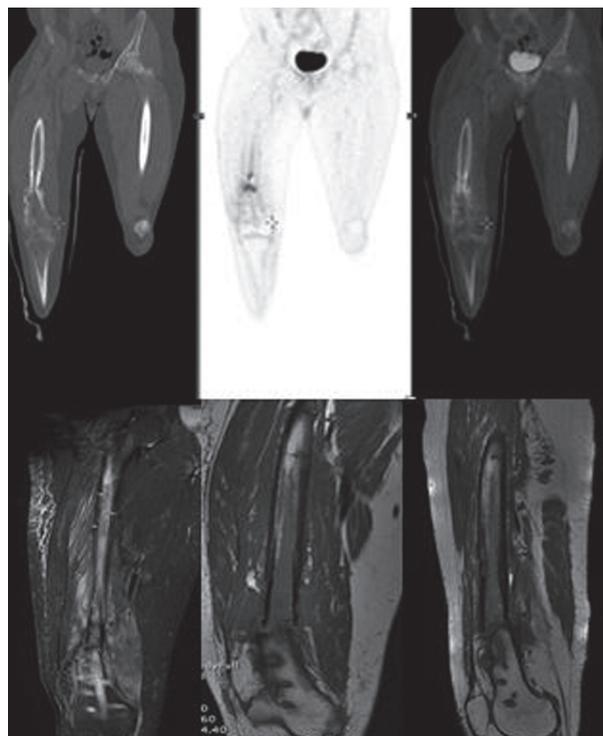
At the top from the right: TC, PET, PET-TC of the patient's femoral septic non-union. The same patient's MRI sequences at the bottom
